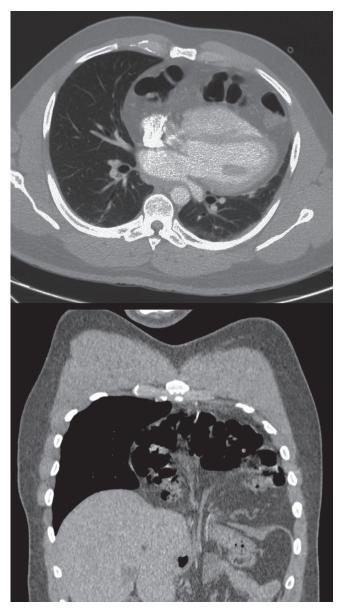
Transverse (top) and sagittal (bottom) computed tomography (CT) images demonstrating posterior displacement of the anterior heart by transdiaphragmatic herniated bowel.
